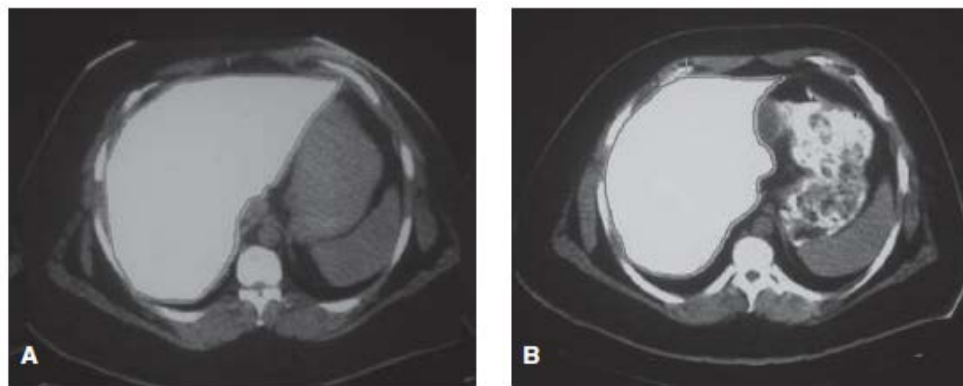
CT before intragastric balloon (A) and after 6 months (B) for measurement of reduction in liver volume.
